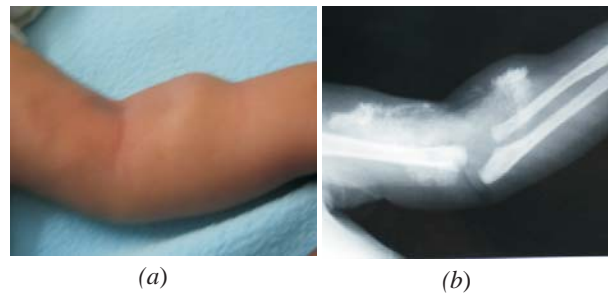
(a) Showing swelling in the upper part of the left forearm, (b) X-ray limb showing subcutaneous calcification.
